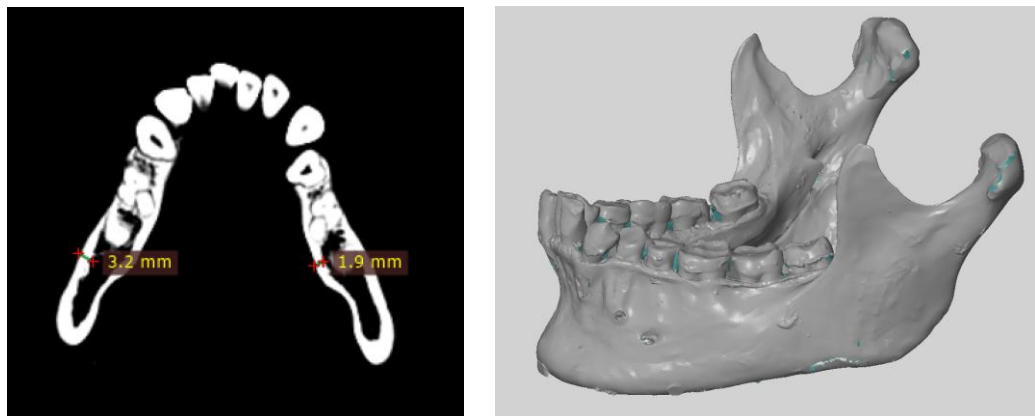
(from left to right) CT scan of the mandible converted into 3D model
